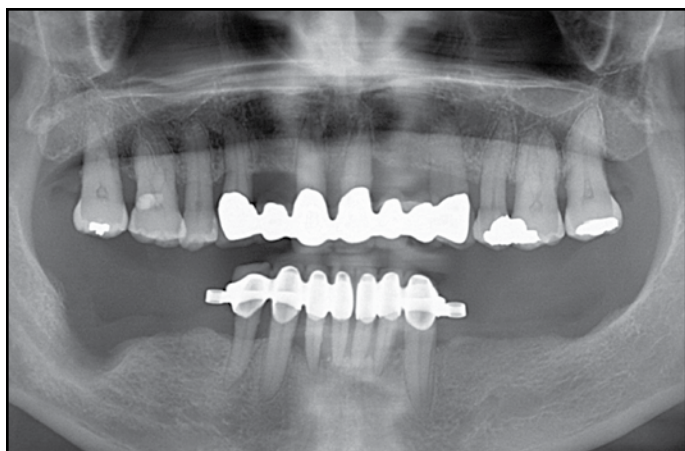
A plain radiograph reveals severe vertical bony deficiency on the right posterior mandible.
